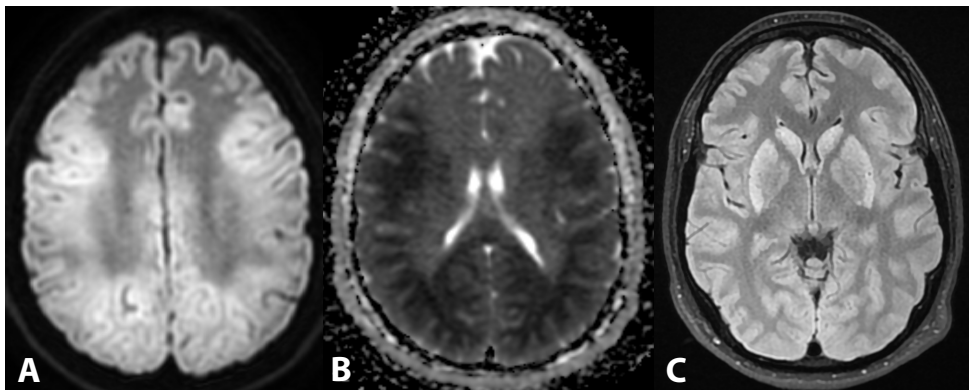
Magnetic resonance imaging with generalised oedema on DWI (A) and reduced diffusion on ADC (B) cortically and subcortically. The T2 FLAIR (C) at 4.5 days post-arrest demonstrates oedema in the basal ganglia (mainly the Caudate nucleus and the Putamen).
